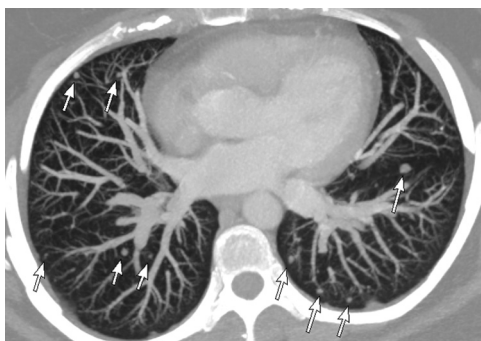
Pulmonary metastases on chest computed tomography (CT). Reconstructed 2 cm thick maximum intensity projection (MIP) image of chest CT demonstrating small bilateral pulmonary nodules (arrows) in random distribution, typical for miliary metastases. Biopsy was consistent with metastasis from patient's primary thyroid cancer. These were new when compared with a prior staging positron emission tomography (PET) scan.
